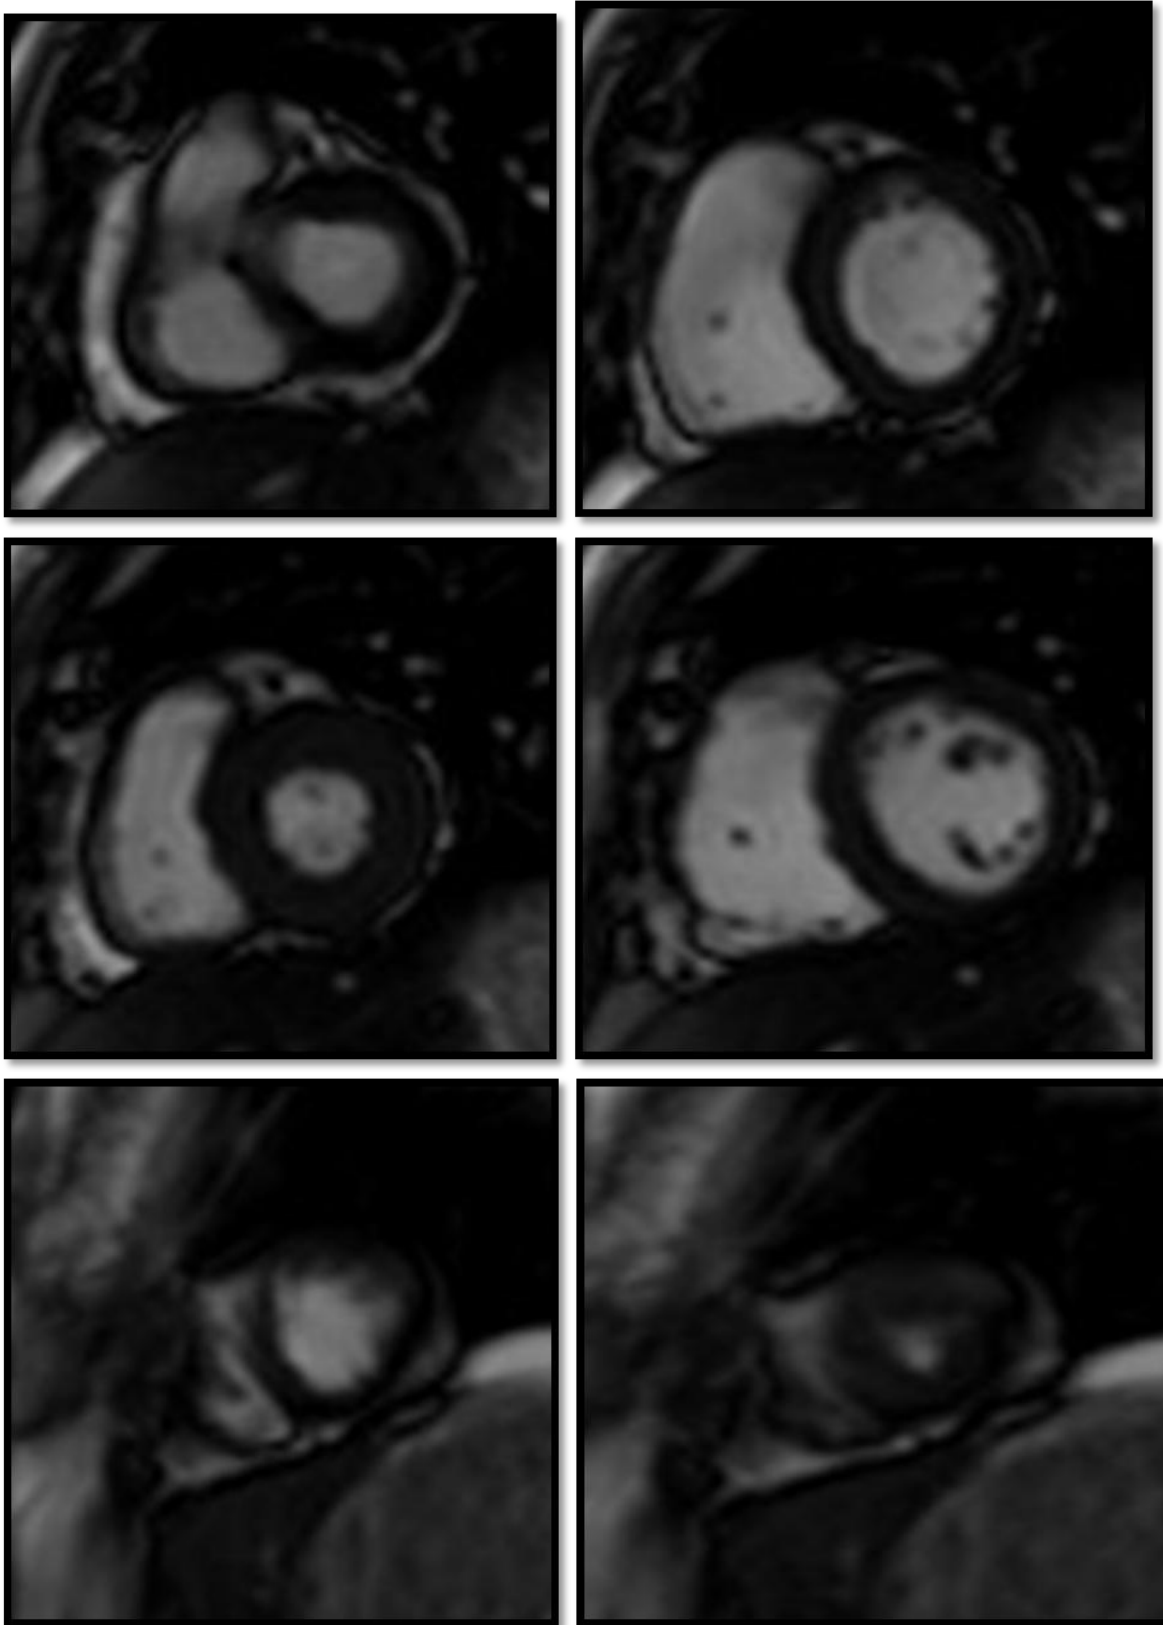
MRI CINE short axis at systole and diastole- basal, midcavity and apical level
